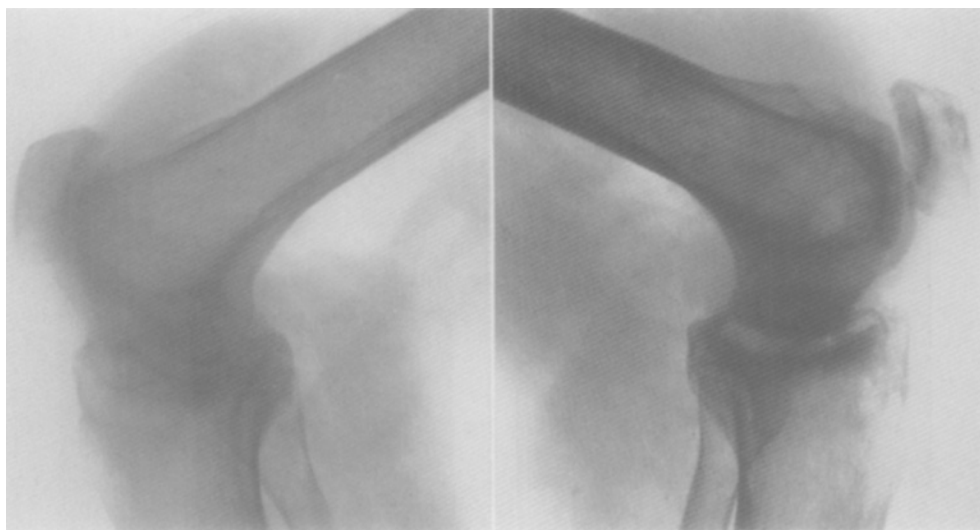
Case 23: roentgenograms of right and left knee in position of maximal extension before operation.
